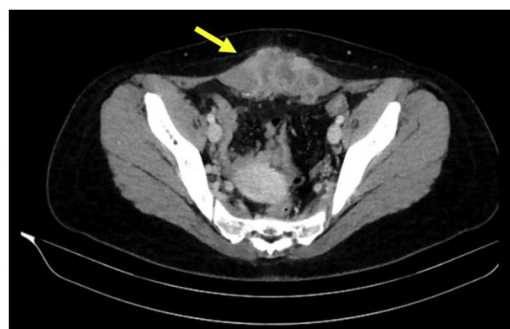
Axial abdominal-pelvic CT scan with intravenous contrast revealing a solid infraumbilical lesion (8 × 8 × 4 cm) occupying both rectus muscles with signs of local invasion, suggestive of a desmoid tumor (yellow arrow); likewise, urachal remnant connecting the umbilicus to the bladder is observed.
